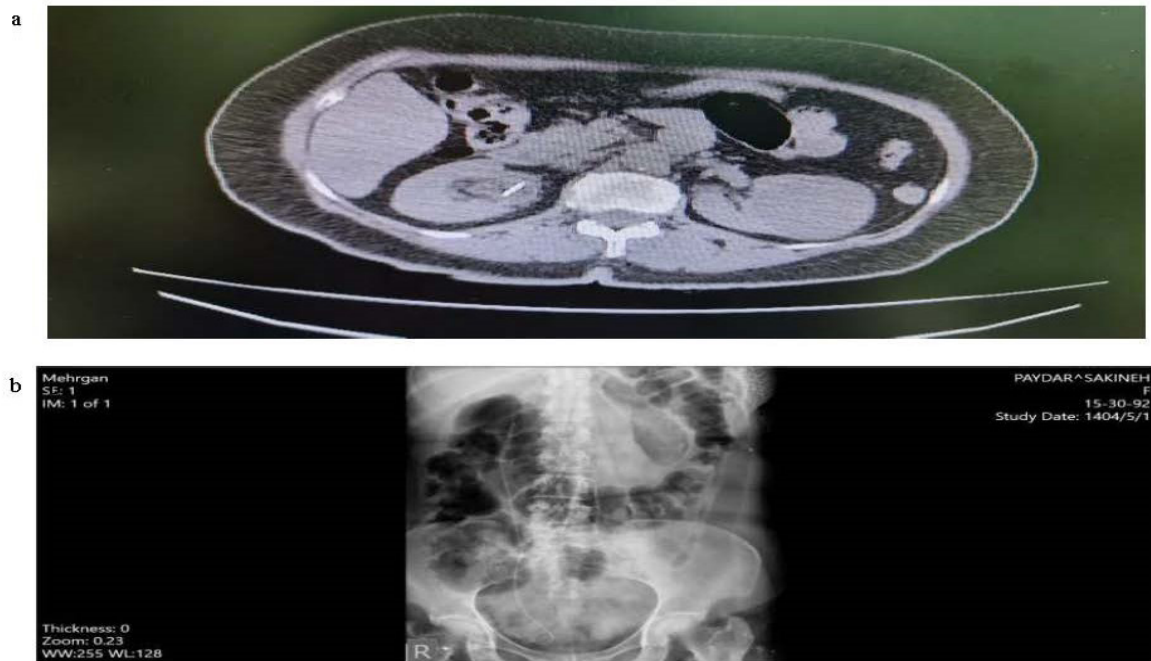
Postoperative computed tomography scan at 1 month showing no residual component of the renal pelvis lesion. A double-J stent is observed in the renal pelvis.
